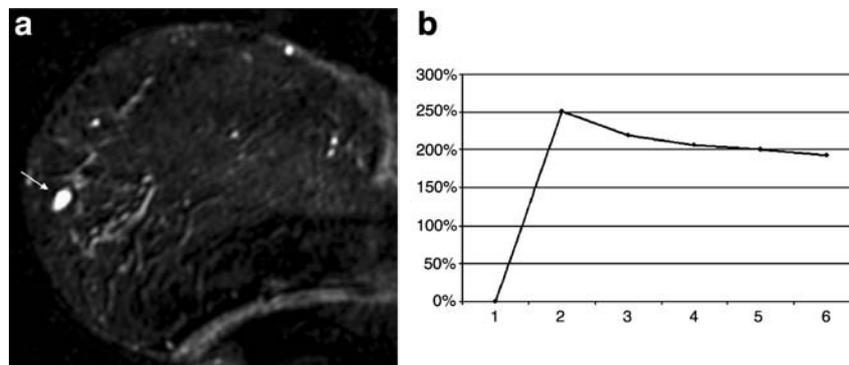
a A coronal subtraction MR image from the right breast of a 49-year-old *BRCA1*-mutation carrier. Lateral located in the right breast, a sharply delineated rounded, homogeneous enhancing lesion is visible with a longest diameter of 9 mm (*arrow*). b The relative
